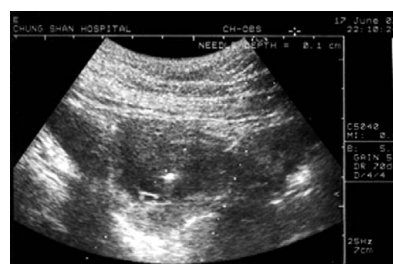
Transabdominal ultrasound with a puncturing device. A 22-gauge needle was inserted into the ectopic gestational sac.
